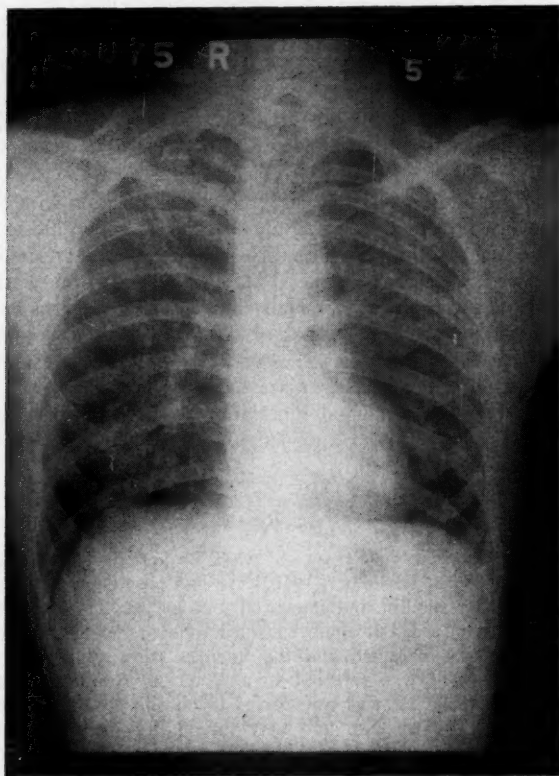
Chest x-ray made during initial hospitalization—five months after onset of symptoms.
